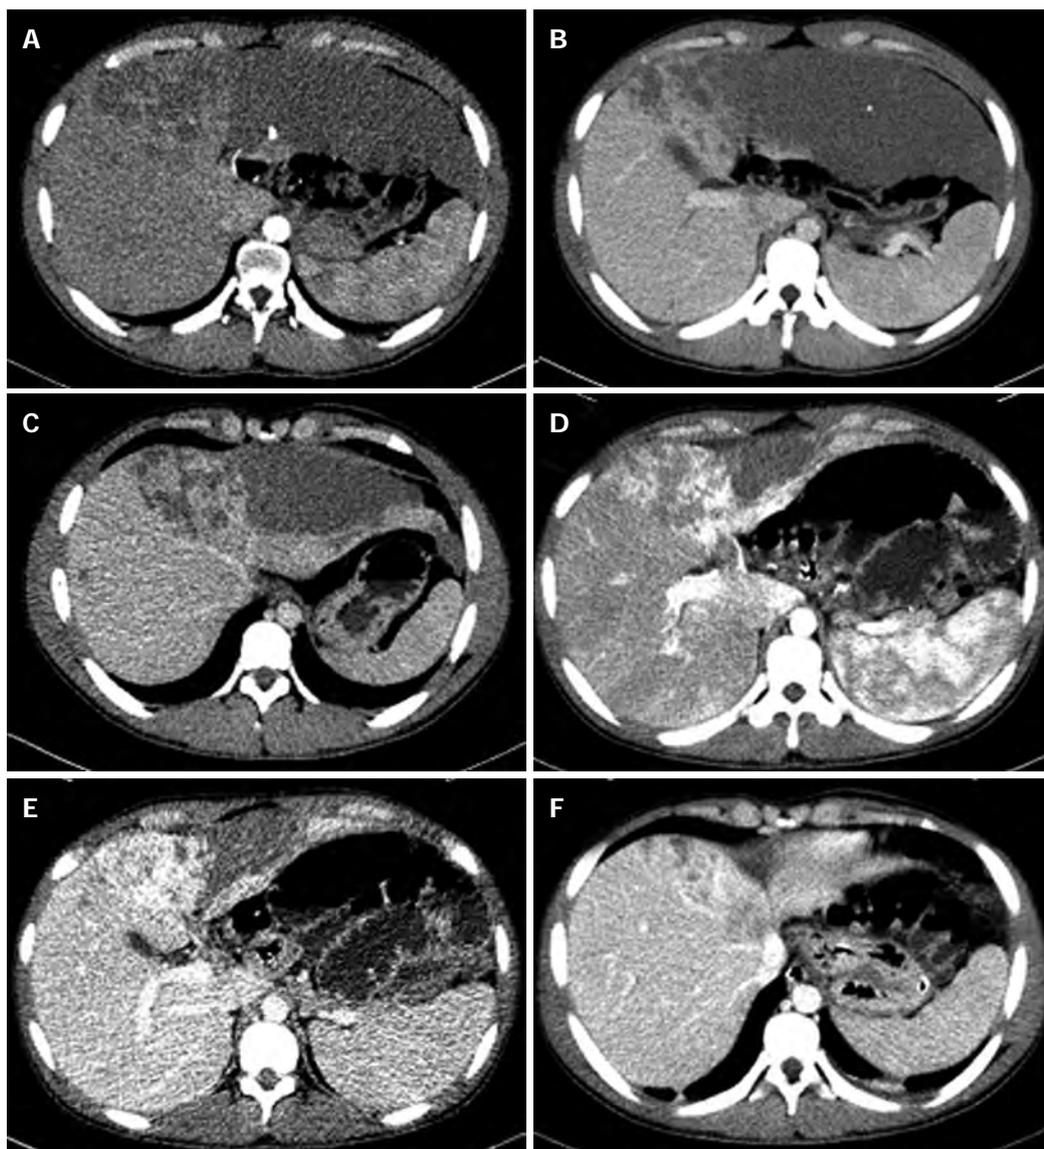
Axial images of multi-detector computed tomography. Multi-detector computed tomography (MDCT) images at the first visit (A-C), and corresponding MDCT slices just before the operation (*i.e.*, one month after transcatheter arterial embolization) (E-G).
